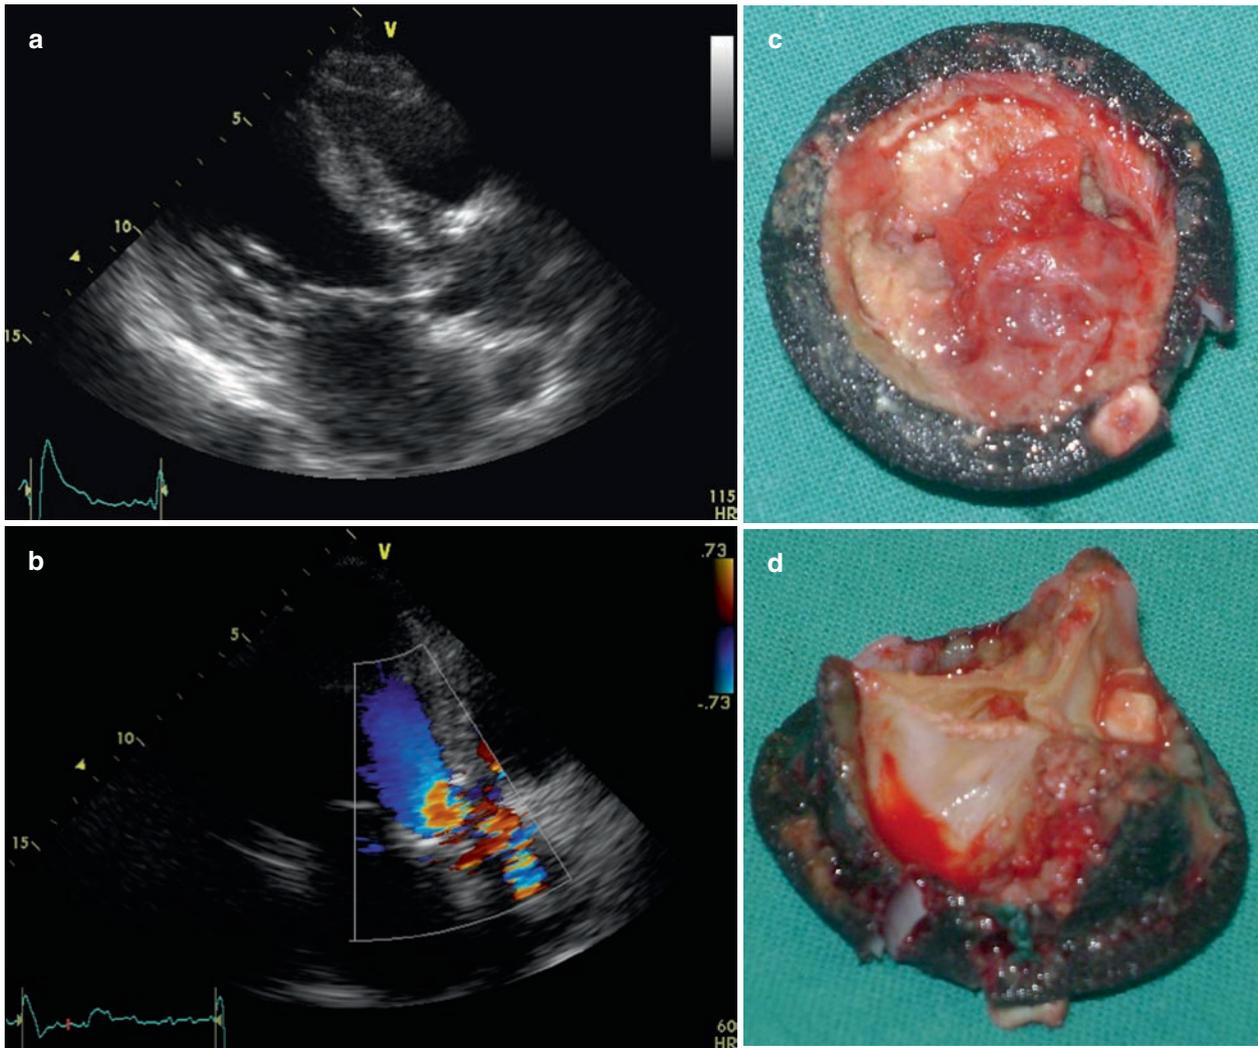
Transthoracic echocardiography showing a large vegetation on the left ventricular side of a bioprosthesis in the aortic position. The vegetation enters the valve orifice during systole obstructing
